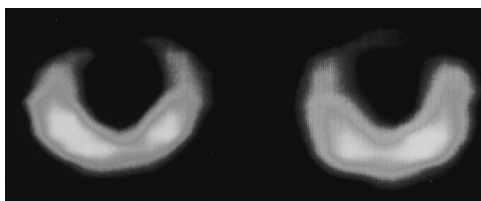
Two short-axis slices from a patient with a flow-metabolism mismatch. In the inferoseptal region, Tl-201 uptake (left) is decreased, with preserved FDG uptake (right) in the septal region. Rest echocardiography revealed akinesia in the inferior and septal regions before revascularization. After intervention, wall motion improved in the septal region. LVEF improved from 29% to 37% after revascularization.
